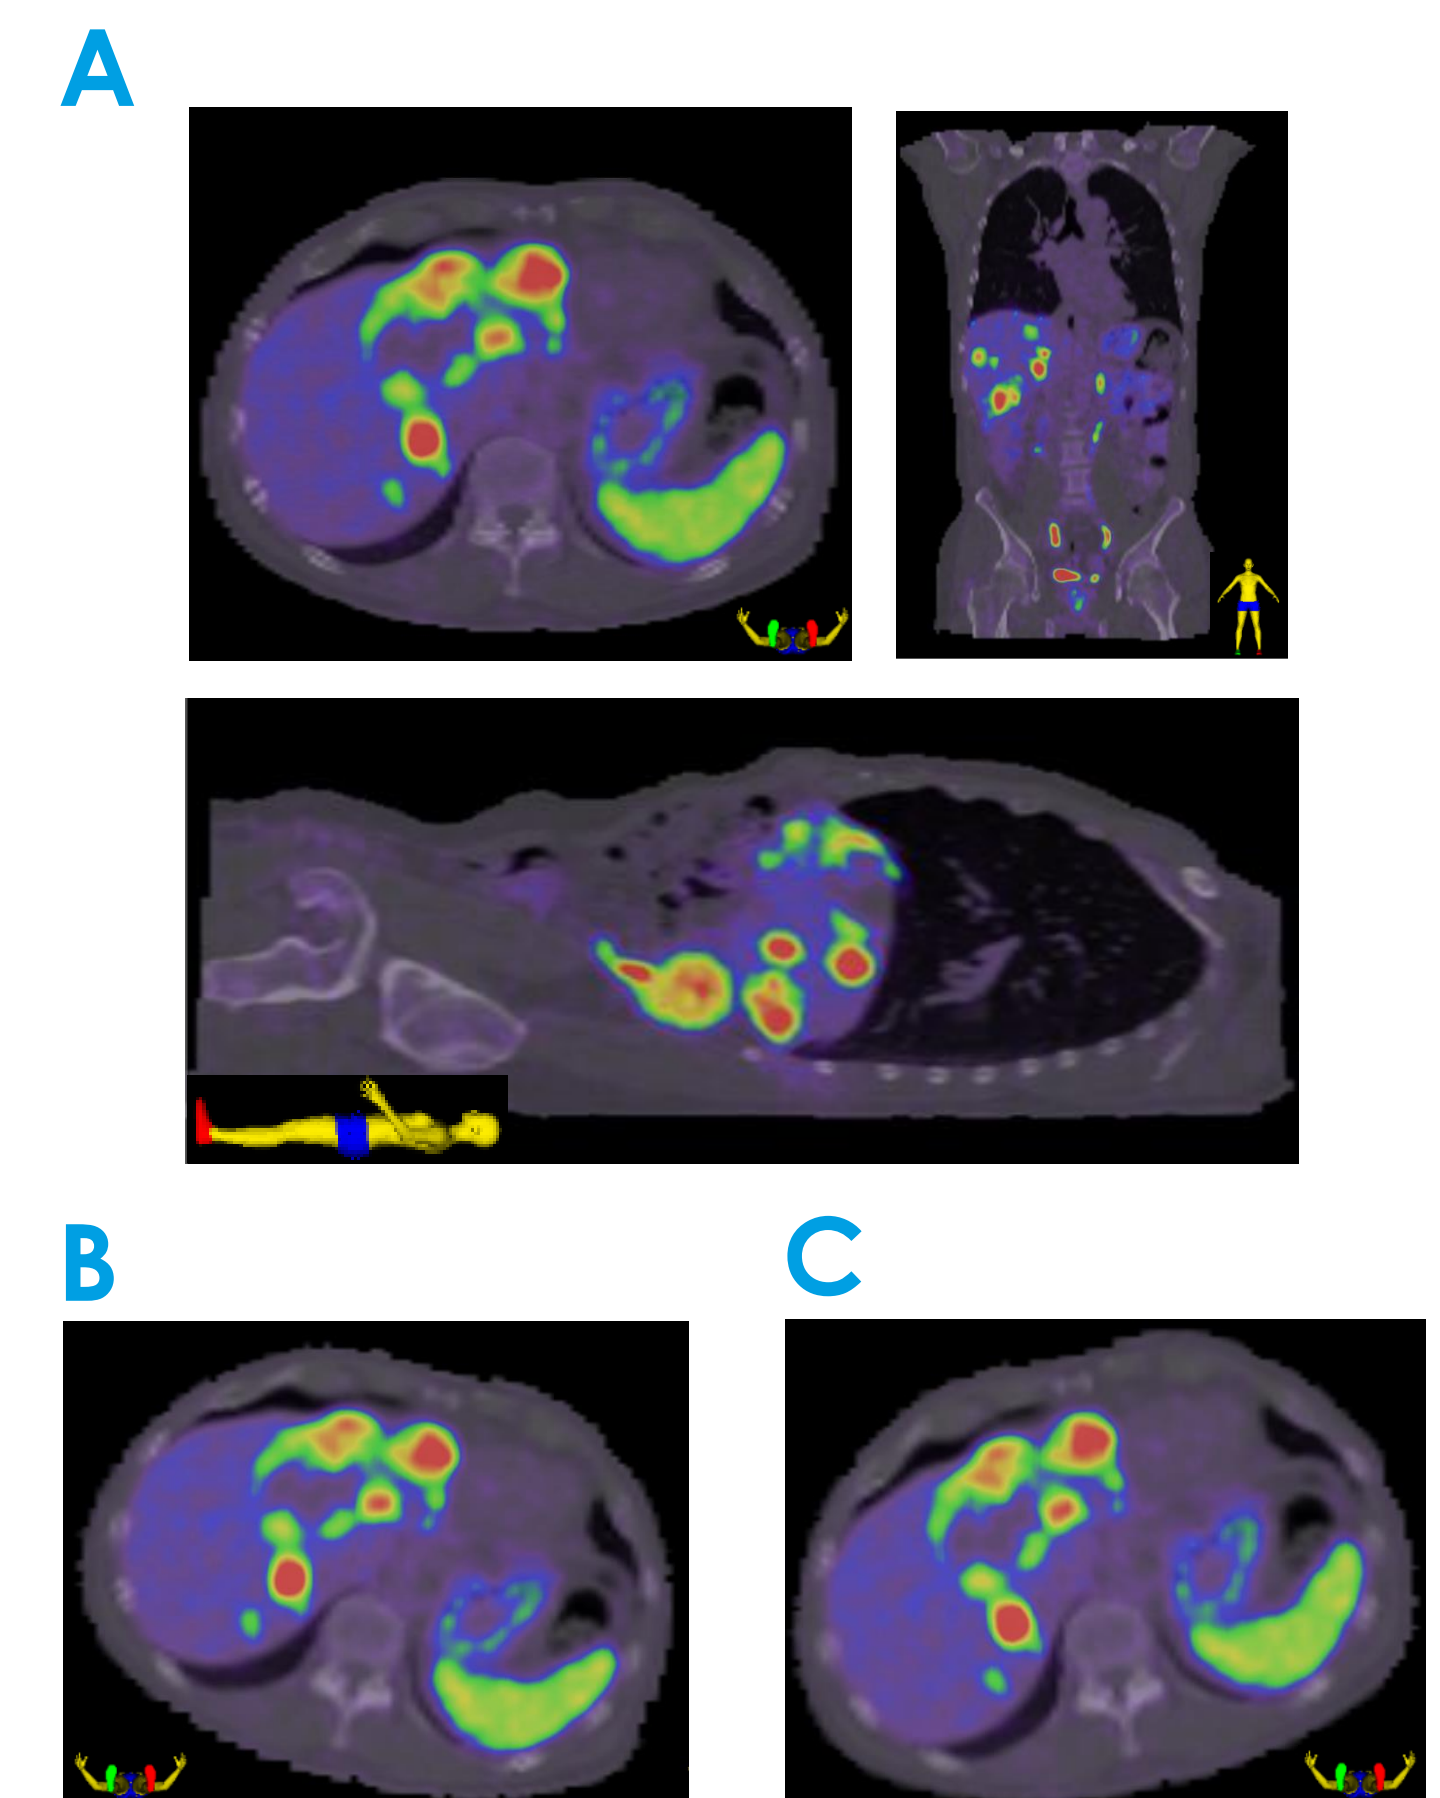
The pre-processed and cropped PET/CT images used as the input for the model in (A) the original image, (B) right rotation and elastic deformation and (C) left rotation and zoom.
